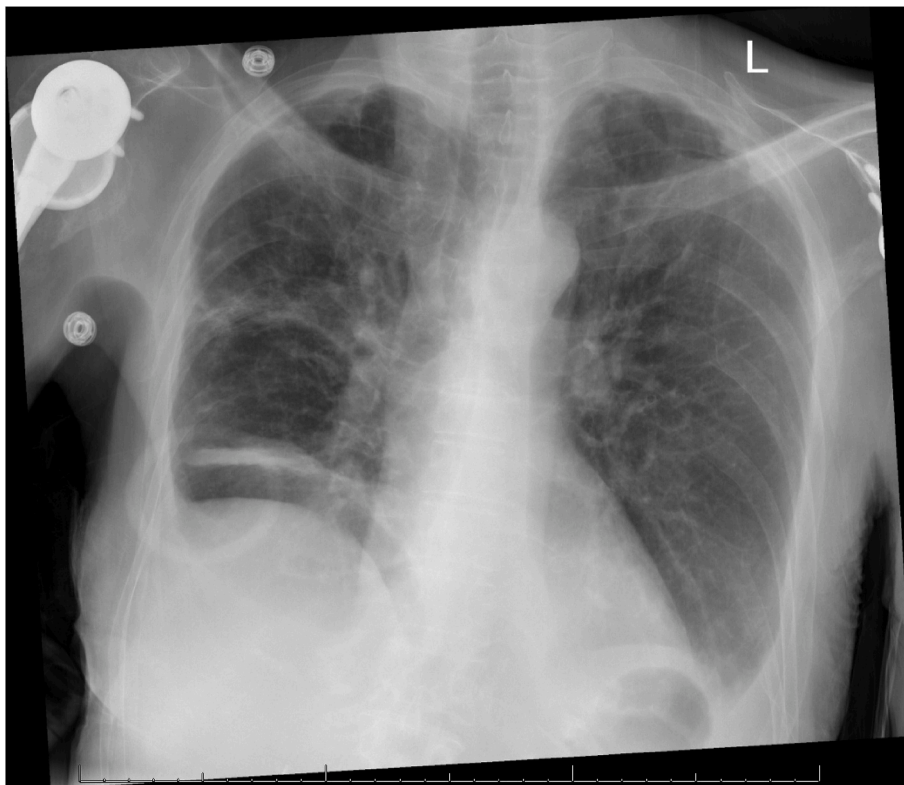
Day 20 final chest x-ray prior to discharge.
